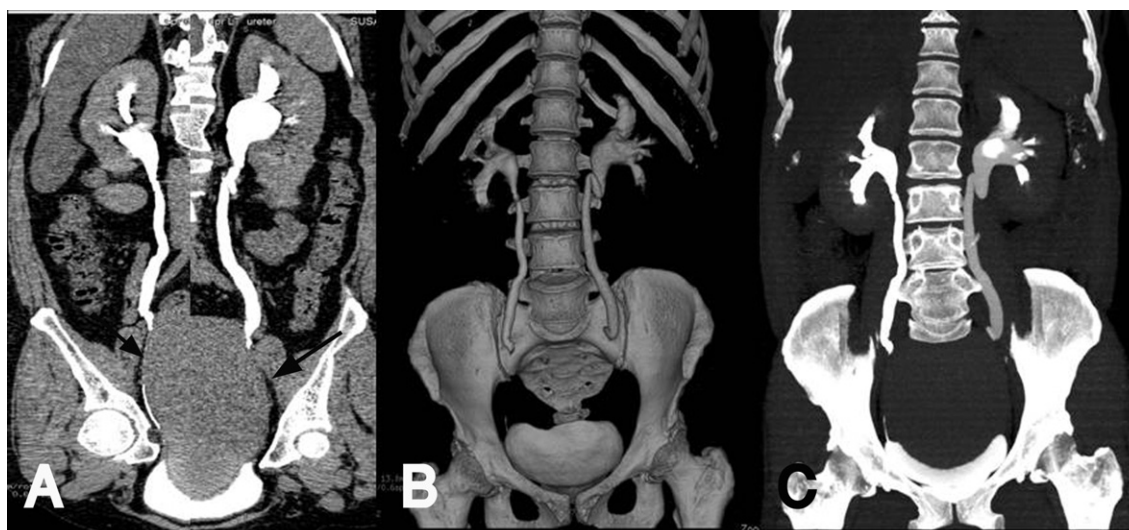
Forty-three year old female presented with bilateral renal obstruction. Coronal CPR (A) in the excretory phase of CT urography clearly shows the cause and level of the obstruction which in this case a large uterine fibroid (black arrows). Reconstructed coronal VR (B) and its corresponding MIP(C) images in excretory phase of CT urography show only the level of the obstruction, while the cause was not detected.
